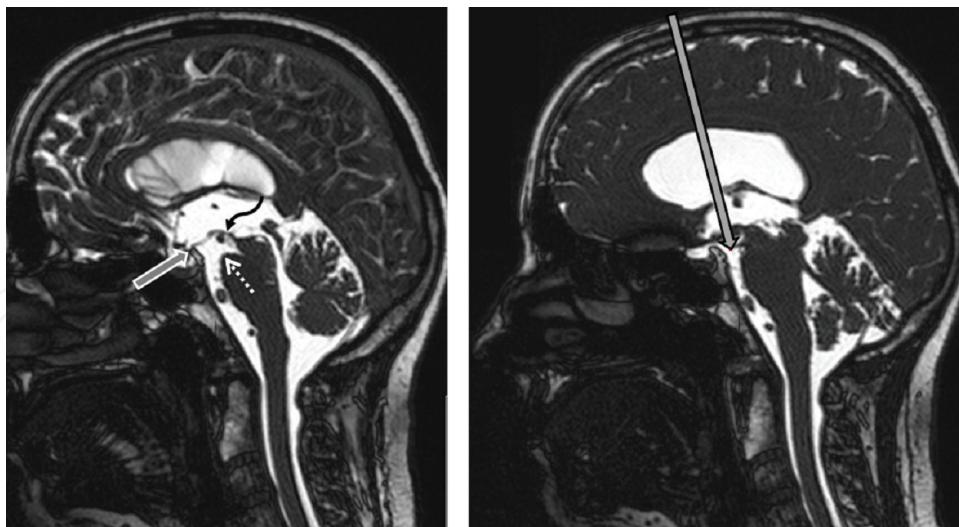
(Left) Landmarks on the MRI scan TRUFI sequence, (L) lateral ventricle, (III.) third ventricle. Infundibular recess (grey arrow), mammillary body (wavy arrow), and interpeduncular and prepontine cistern (dotted arrow). (Right) Entry point.
